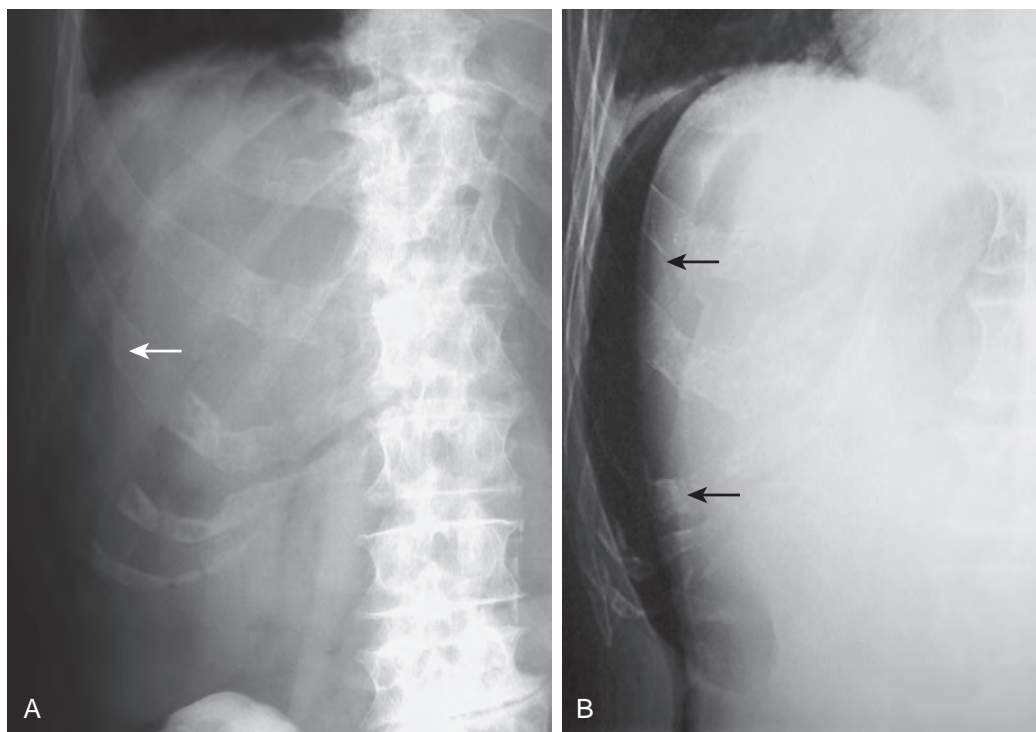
Value of upright abdominal radiograph in patients with small bowel obstruction or intestinal perforation. A. Supine abdominal radiograph shows a relatively gasless abdomen in a patient with signs and symptoms of intestinal obstruction. B. Upright radiograph shows multiple tiny air-fluid levels (arrows) caused by fluid-filled loops of dilated small bowel with trapping of air superiorly in these loops (producing the string of pearls sign). The patient was found at surgery to have a closed loop small bowel obstruction due to adhesions. C. Supine abdominal radiograph in another patient with abdominal pain shows no evidence of pneumoperitoneum. Note residual contrast material in the colon from a prior study. D. Upright abdominal radiograph in the same patient as in C shows a large amount of free intraperitoneal air (arrows) beneath both hemidiaphragms. E. Upright radiograph in another patient shows a tiny amount of free air (arrows) between the liver and right hemidiaphragm.
